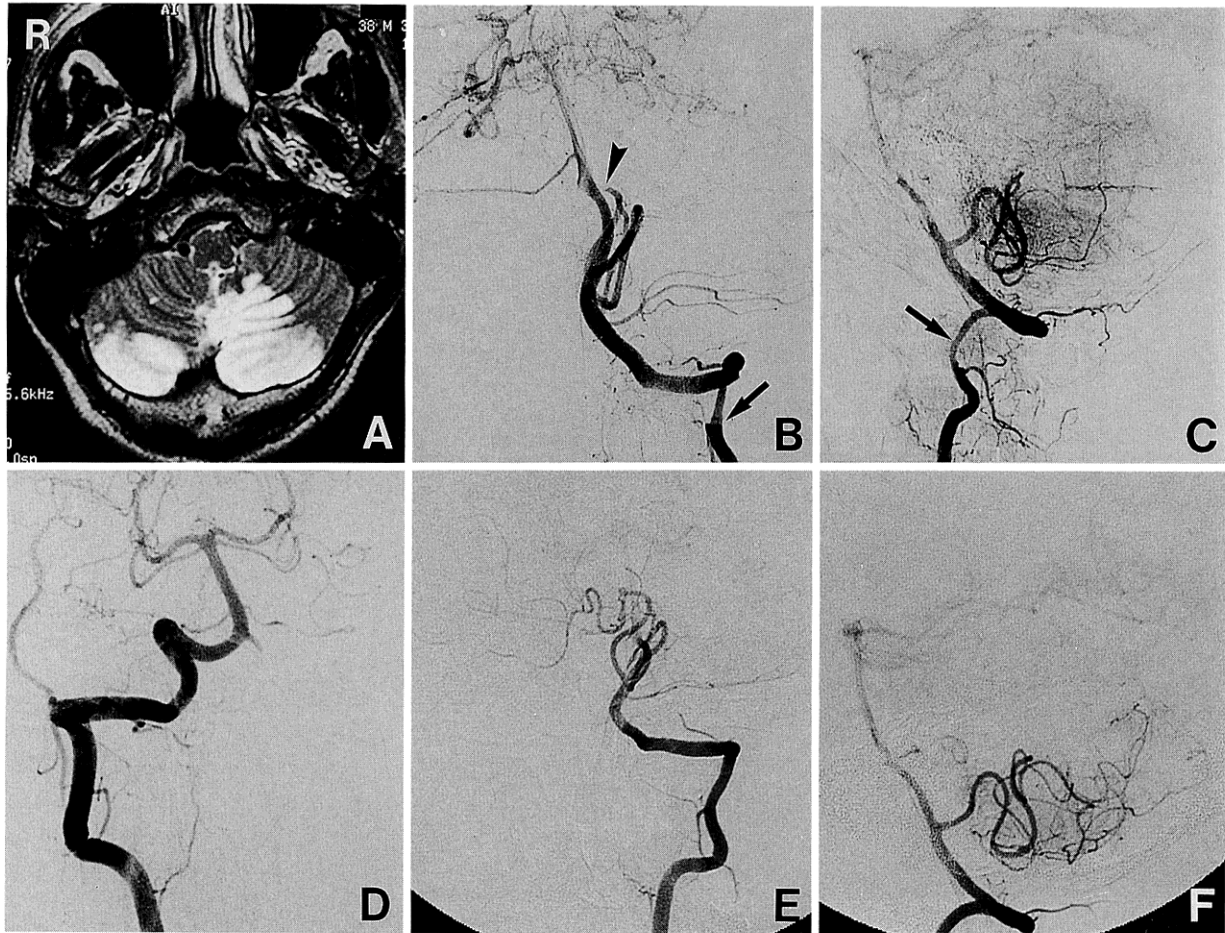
Case 2. Magnetic resonance image on day 2 (A) showing bilateral inferior cerebellar infarctions (left > right). Left vertebral angiograms on day 3 (B: frontal view, C: lateral view) showing stenotic change in the V₃ segment of the left vertebral artery (arrow), and capillary blush and occlusion of the left posterior inferior cerebellar artery (PICA) (arrowhead). Right vertebral angiogram on the same day (D: frontal view) showing no apparent PICA on the right side. Follow-up angiograms on day 38 (E: frontal view, F: lateral view) showing resolution of the stenosis in the V₃ segment and recanalization of the left PICA.
